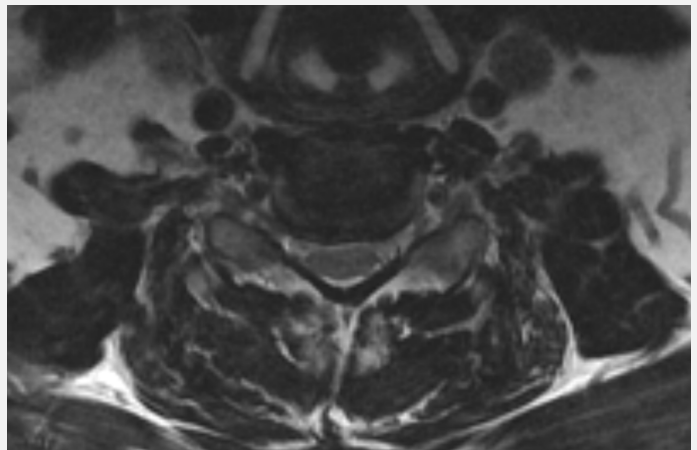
Pre-operative MRI | C5-6 showing central disc herniation causing central and some right-sided foraminal stenosis
